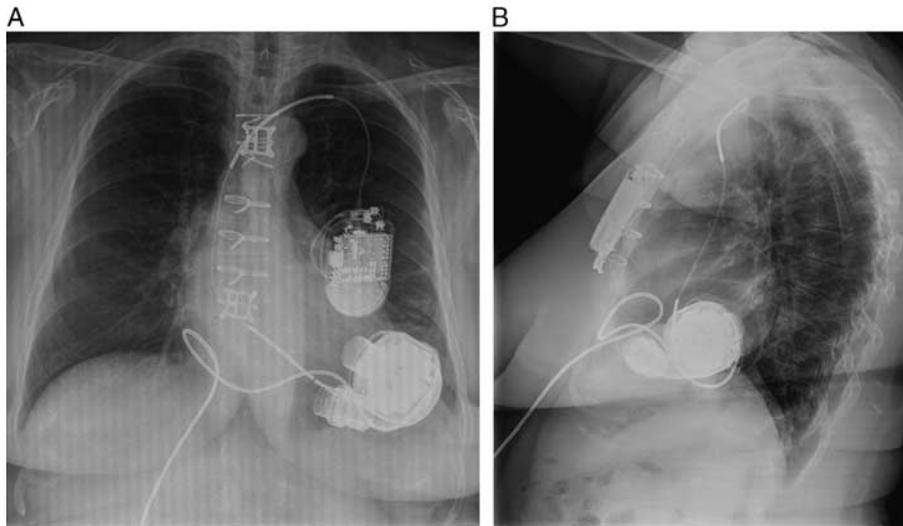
Third-generation Heartmate III LVAD: frontal (A) and lateral (B) radiograph depicting Heartmate III LVAD. The monoblock design enables an intrapericardial position with both inflow and outflow within 1 apparatus.
